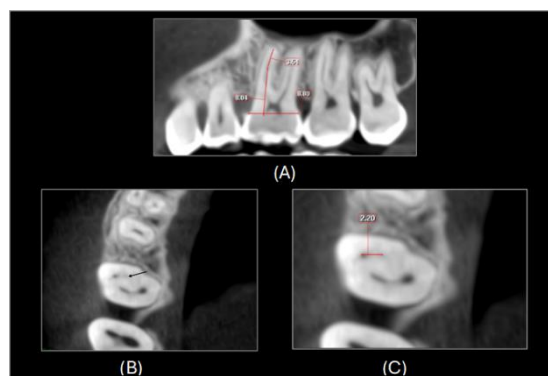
CBCT reconstructions of the MB root in the maxillary first molar tooth. (A) Root length measurement in the sagittal section, (B) The first axial section in which the MB2 canal was visualized and (C) ICD measured between the MB1 and MB2 canal
